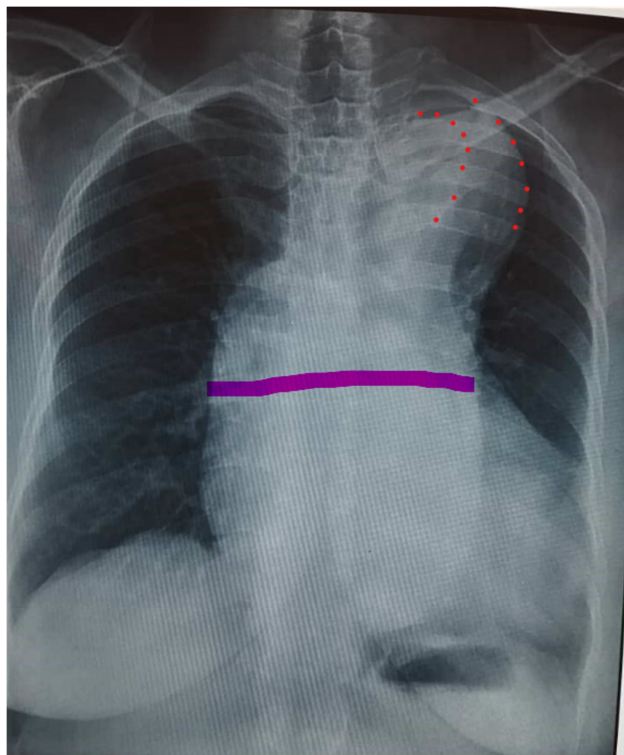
Chest x-rays of a patient with Stanford type A aortic dissection at the CNHU-HKM in Cotonou, Benin, showing enlargement of the mediastinum (solid line) and a double-contour image of the aortic arch (dotted line).
